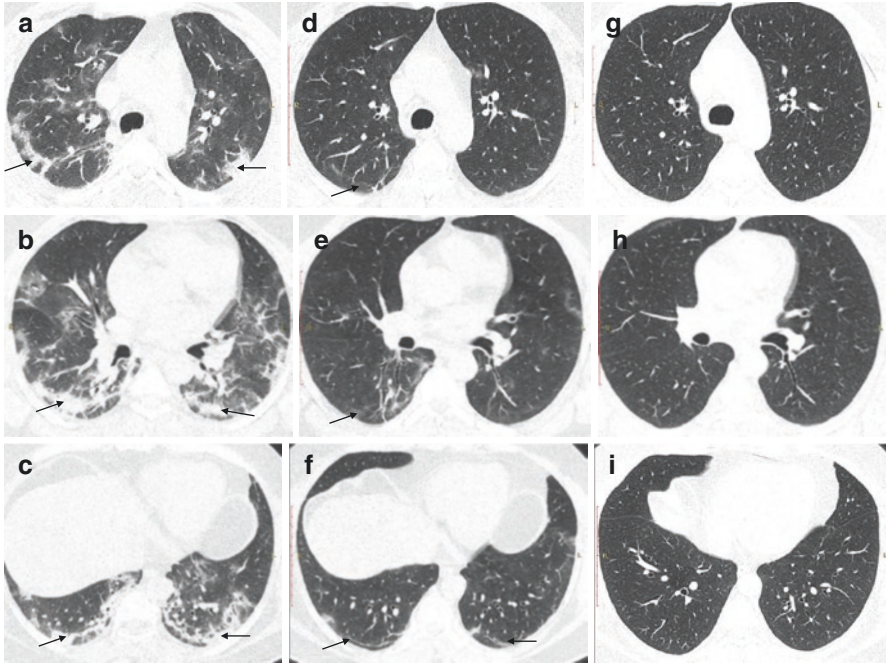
Follow-up CT scans of a 56-year-old male with COVID-19 pneumonia. CT done in the first week of illness shows multifocal subpleural areas of organizing pneumonia (arrows in a, b, c). Follow-up CT done 3 months later (arrows in d, e, f) shows partial resolution with residual subpleural bands, and CT done 1 year later (g, h, i) shows complete resolution
